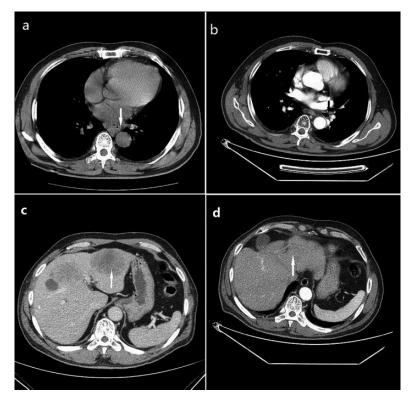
Abdominal computed tomography showed the medial and lower esophageal wall (a) before treatment and (b) after treatment and the liver metastases (c) before treatment and (d) after treatment. The arrows indicate the locations of the esophageal lesion and liver metastatic lesion.
